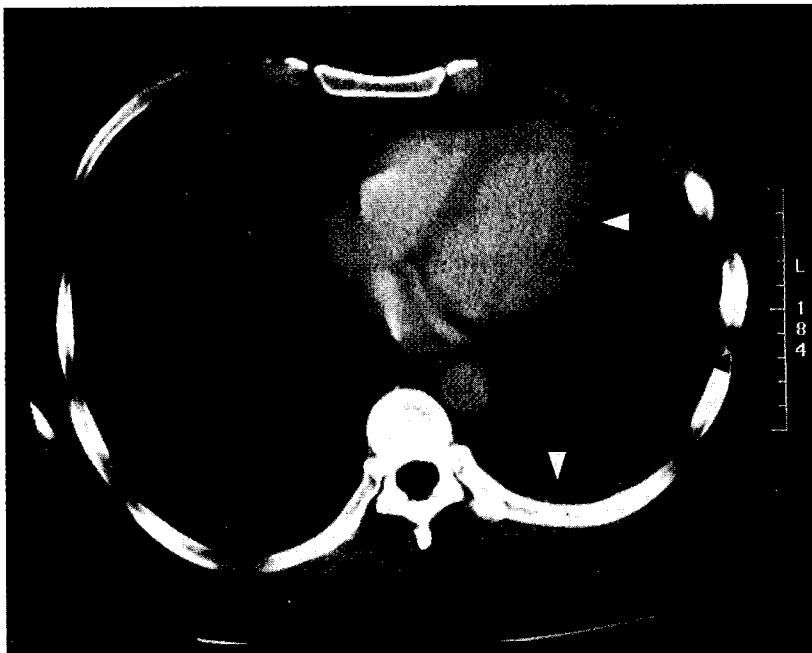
Computed tomography scan of chest without intravenous contrast shows a circumferential thickening of the left pleura and adjoining pericardium (black arrows). Localised left pneumothorax and pneumopericardium suggest communication with the chest wall fistula tract (white arrow heads).
